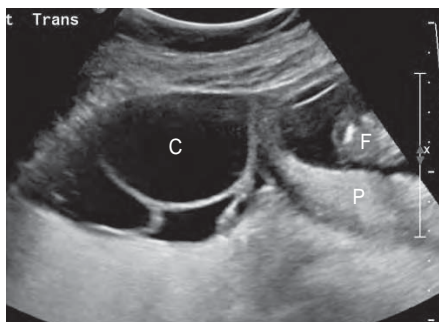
Sonogram showing a multiloculated ovarian cyst (C) identified at the left side of the pregnant uterus. F = fetus, P = placenta.
